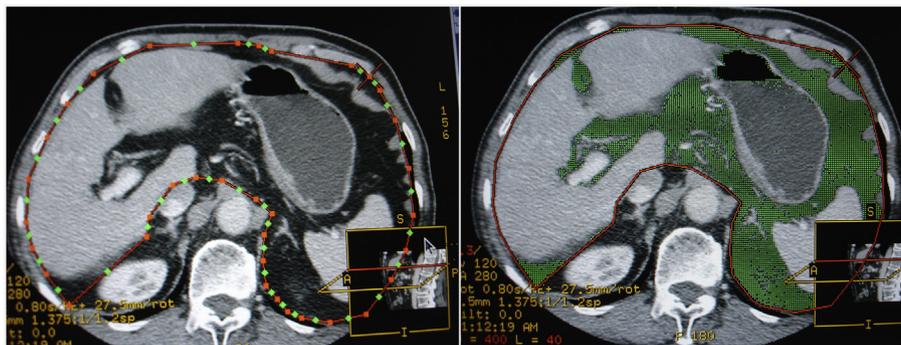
Distribution of intra-peritoneal fat as measured by Advantage Workstation 4.2 G.E. on a CT scan at the portal vein level. The visceral fat area was regarded as green.
